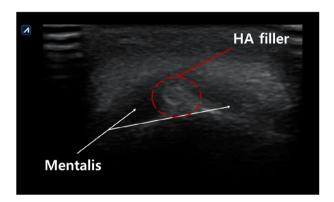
The ultrasonographic observation of the paradoxical masseteric bulging. Hypercontraction of the deep part of the mentalis muscle tends to contract more strongly when the botulinum neurotoxin has not been adequately dispersed. Additionally, inactive granulomas of the hyaluronic acid filler were observed between both sides of the muscle belly.
